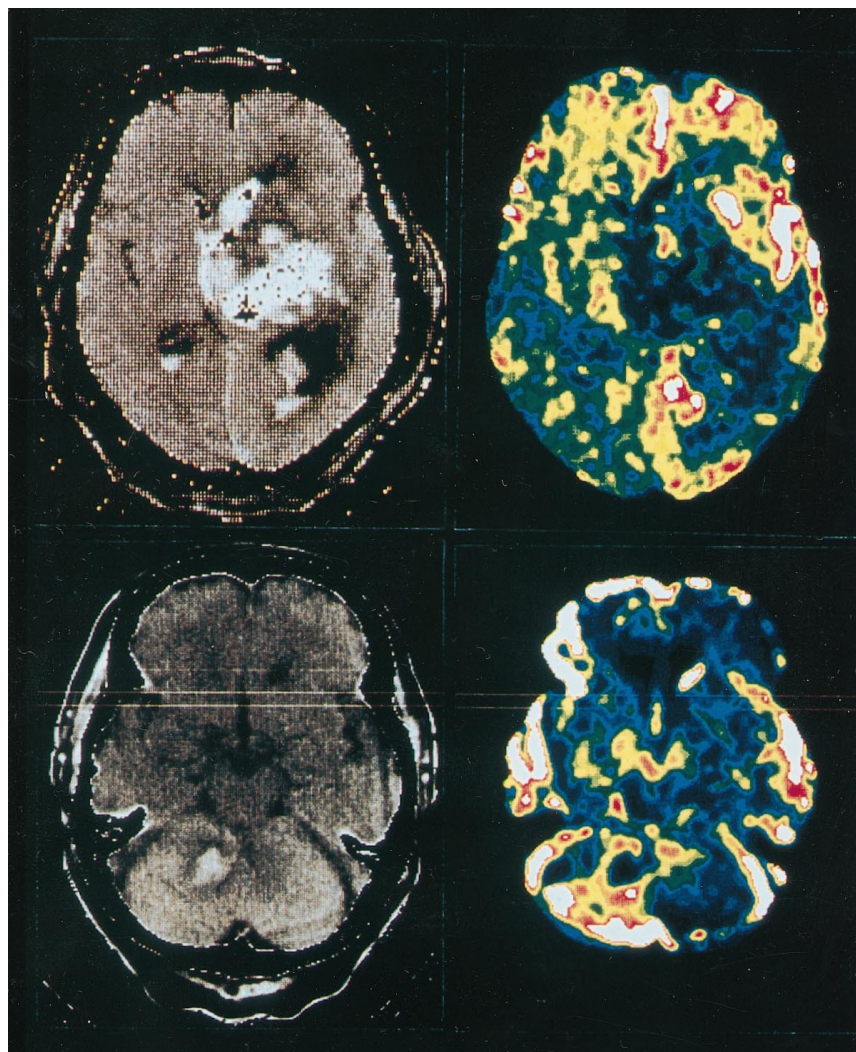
CT scans (*left*) and regional cerebral blood flow (rCBF) maps (*right*) 2 days after the onset of putaminal hemorrhage (*above*) and 3 days after the onset of cerebellar hemorrhage (*below*). The rCBF maps show the defect in the hematoma surrounded by areas of hyperemia lateral, anterior, and posterior to the hematoma (*above*) and the defect in the hematoma surrounded by areas of hyperemia posterior to the hematoma (*below*).
